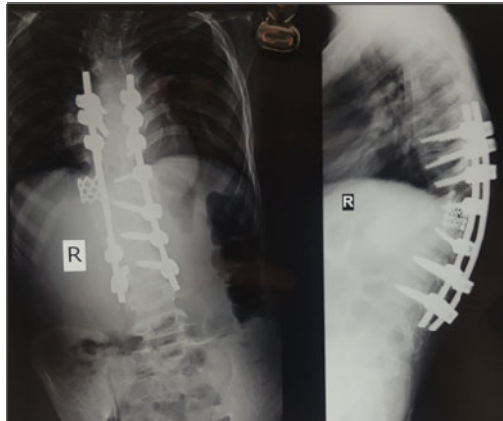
Postoperative day 14 radiograph anteroposterior and lateral view of spine depicting correction of kyphoscoliosis with cage, bone graft, pedicular screws and titanium rods in place.
